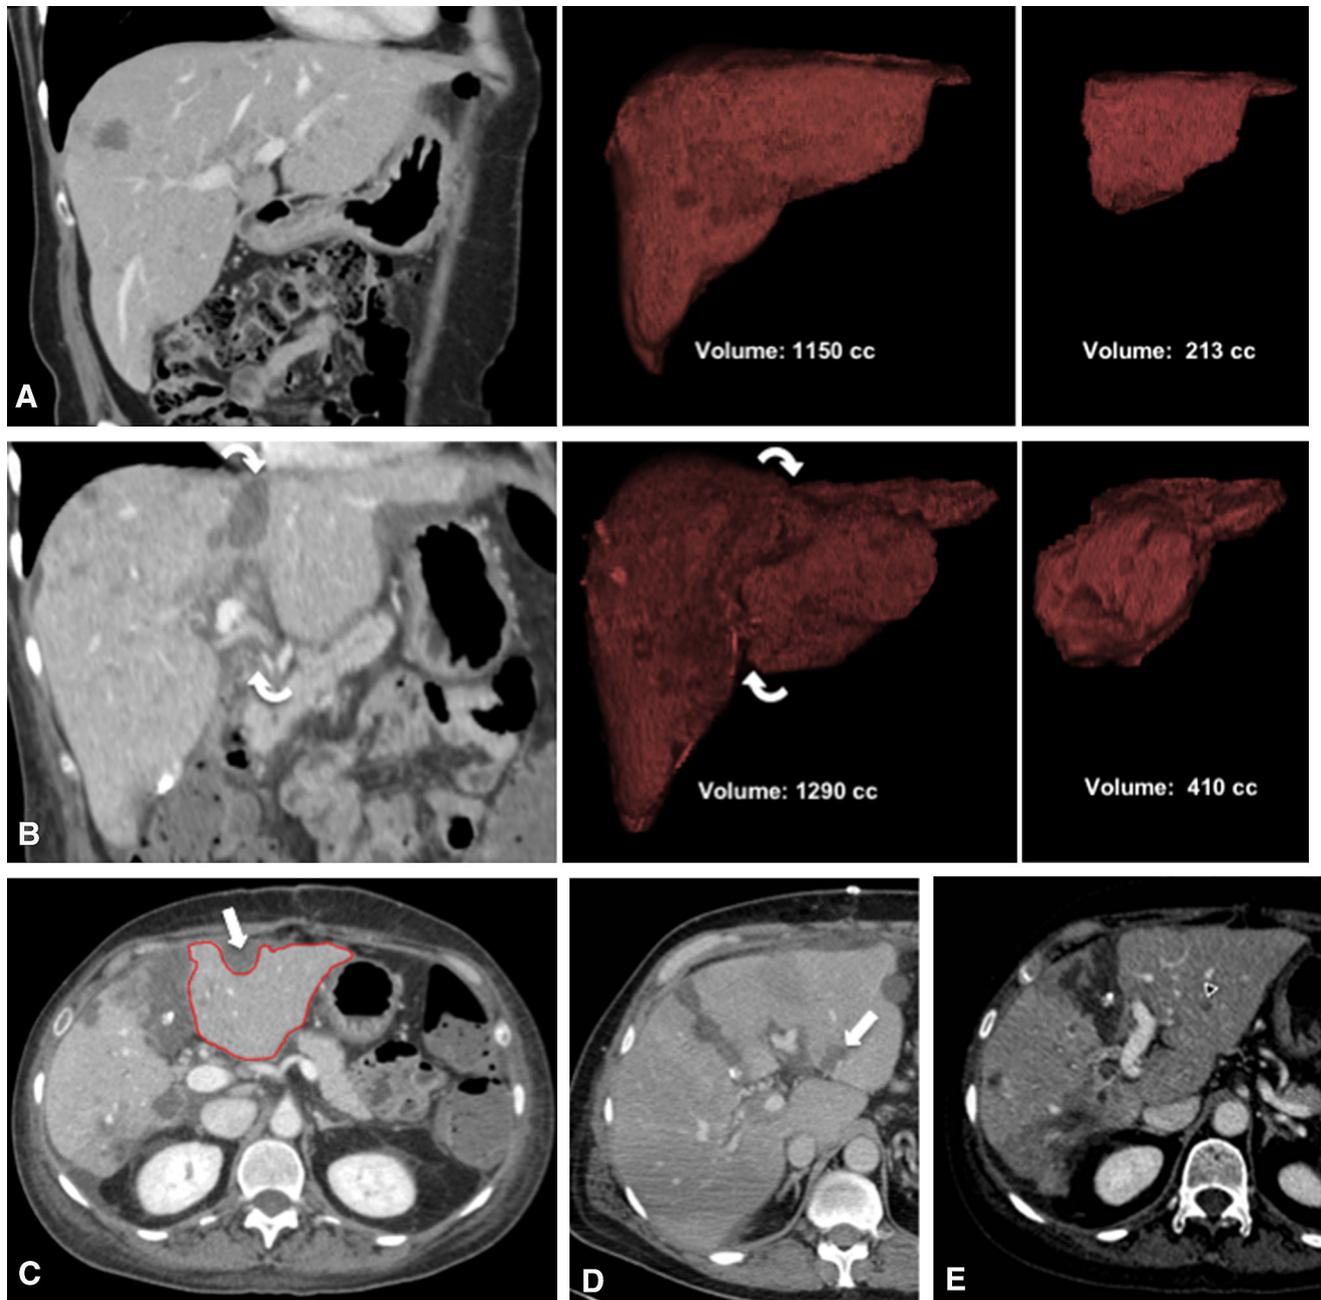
Second imaging (IM2): recalculation of FLR and pitfalls: Prior to the second step, typically after 14 days, a second CT scan is performed. The total liver volume and the future liver remnant (FLR) volume are calculated, always in the portal venous phase. A Coronal image (A1) and 3D reconstructions indicate the total liver volume (A2) and FLR volume (A3) prior to ALPPS (IM1); here, the total liver volume was 1150 cm³, and the remnant liver segments were 213 cm³ in volume (19% of the total volume). B Coronal image (B1) and 3D reconstructions
